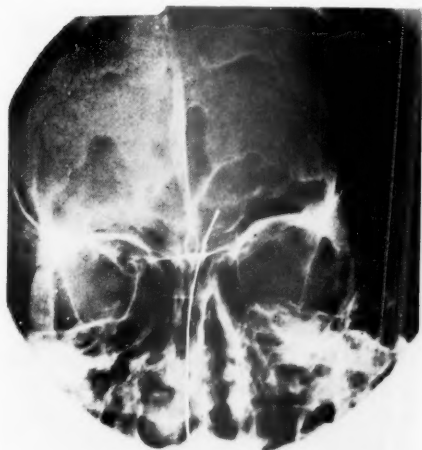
X-ray film of the frontal sinuses in Case 7. Note the probe passing from the right nostril into the left frontal sinus, the cloudiness and indistinct margins of the right frontal sinus, and the formation of sequestra in the right frontal sinus area.
